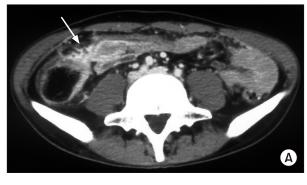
(A) An abdominal computed tomography scan disclosed circumferential mural thickening involving the ascending and transverse colon. Note the stricture at the hepatic flexure (arrow) and mesenteric inflammation. (B) Gastrographin enema radiograph disclosed shortening of the ascending colon with surface irregularity and marked stricture at the hepatic flexure (arrow).
